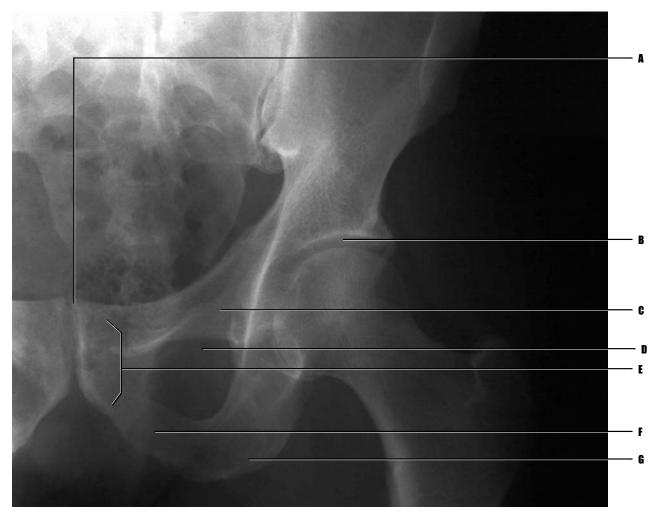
Adult patient, plain film radiograph of left hemipelvis.
